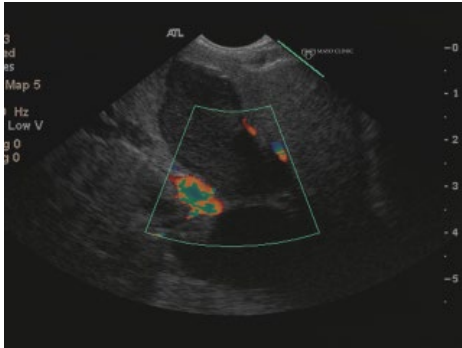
Endoscopic ultrasound image of an established benign lymph node.
